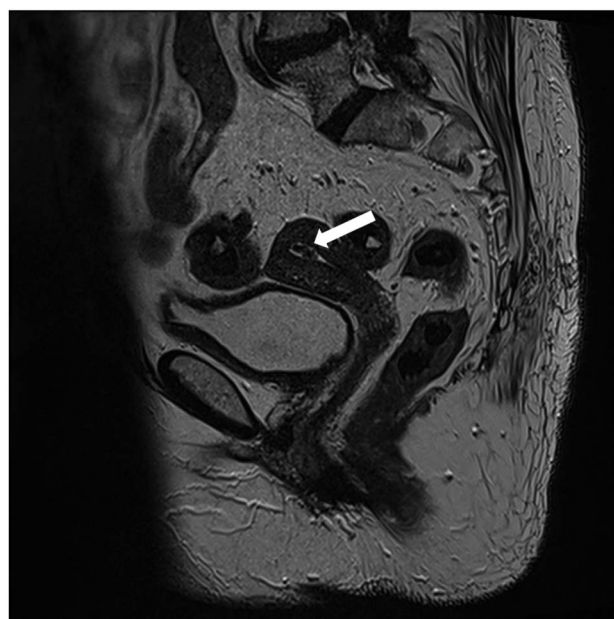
Endometrial polyp. Sagittal T2 small FOV image of a 78-year-old woman for further assessment for an excised rectal polyp, showing an endometrial polyp (arrow), which was subsequently confirmed on transvaginal ultrasound.
